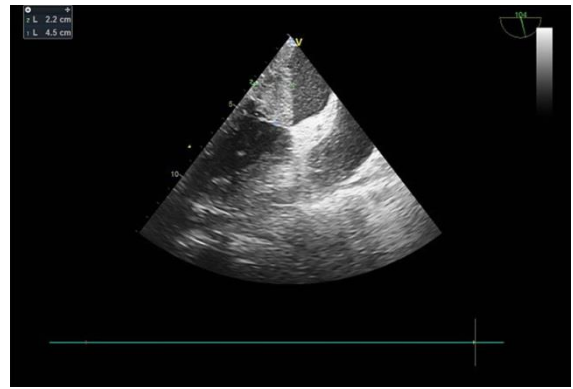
Transesophageal echocardiogram showing mass (42x22 mm) in the left atrium adhering to the posterior region that extended towards the mitral valve, suggestive of a myxoma
